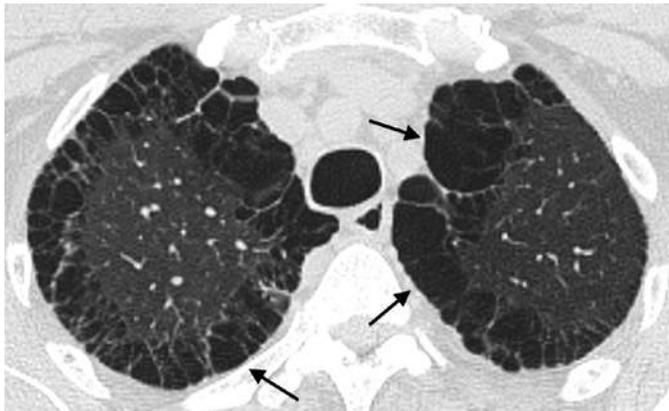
Computed tomography image through the upper lobes in a patient with pulmonary emphysema. Numerous cystic lucencies are present in both lungs. Note the absence of bronchovascular markings within the lucencies. Most of the emphysematous areas are located in a peripheral distribution (arrows) along the pleural surface, representing paraseptal emphysema.
